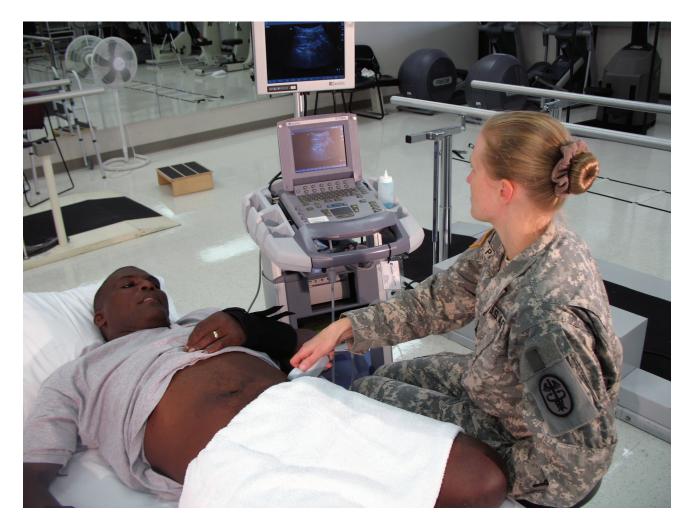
Elizabeth Painter uses ultrasound to identify the transverse abdominis muscle of Gregory Gadson and provide visual feedback for muscle reeducation.
